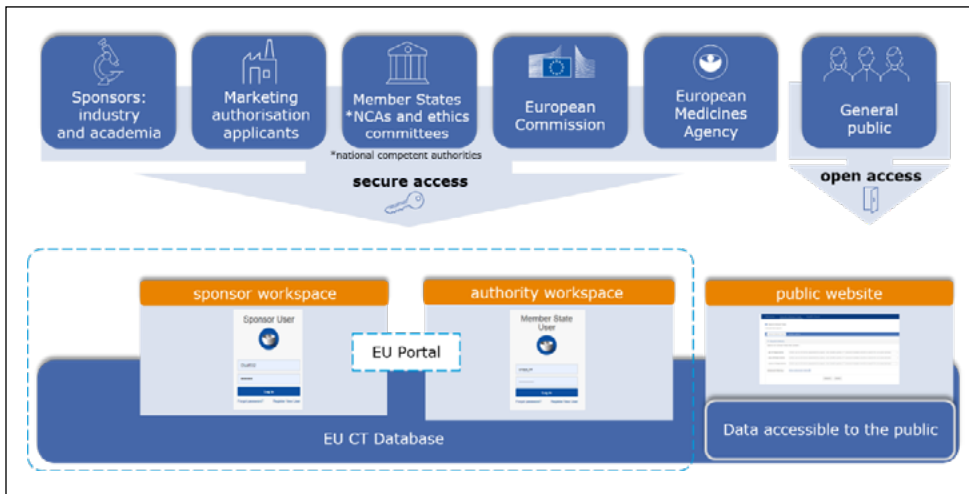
CTIS as a collaborative workspace for authorization, maintenance, and reporting of results of clinical trials in the EU and EEA. CT, clinical trial; CTIS, Clinical Trial Information System; EEA, European Economic Area; EU, European Union. Source: [Sponsor Handbook, v6.1, Introduction and general principles](#).³
